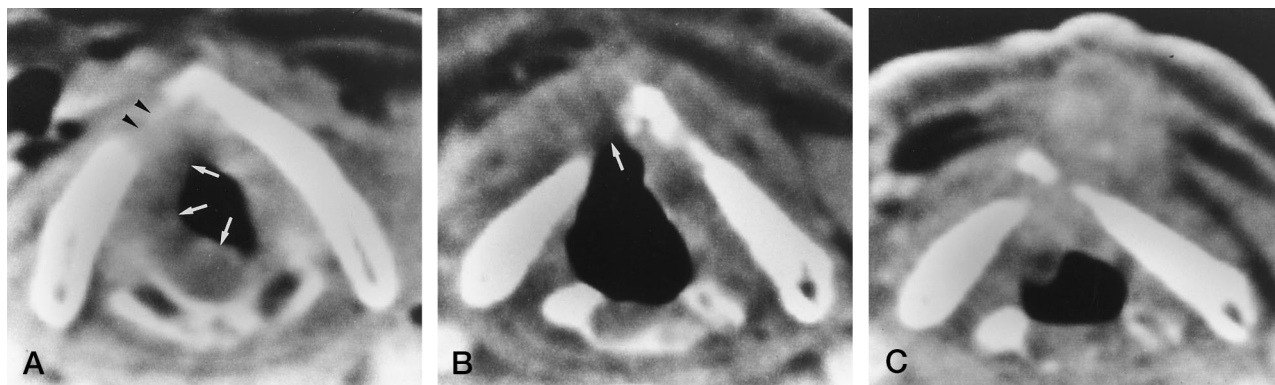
A, Pretreatment CT scan of a patient with a stage T3N1 glottic carcinoma shows thickening of the right true vocal cord, extending into the subglottic region (arrows). The focal defect in the right thyroid lamina (arrowheads) is suggestive of cartilage invasion.
